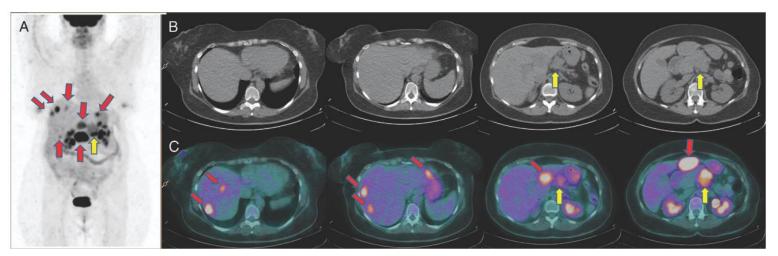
To assess glucose metabolism of tumor lesions, which in turn reflects the proliferative activity of tumor cells, the patient underwent a ¹⁸F-FDG PET/CT. MIP PET image (A), axial CT (B), and PET/CT (C) images revealed increased radiopharmaceutical uptake in the pancreatic mass (yellow arrow) and in multiple liver lesions (red arrows).
